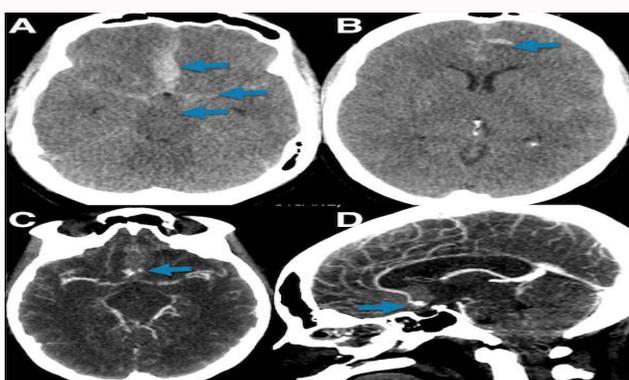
Brain computed Tomography (CT) revealed SAH and Computed tomography angiography (CTA) revealed a saccular aneurysm:
